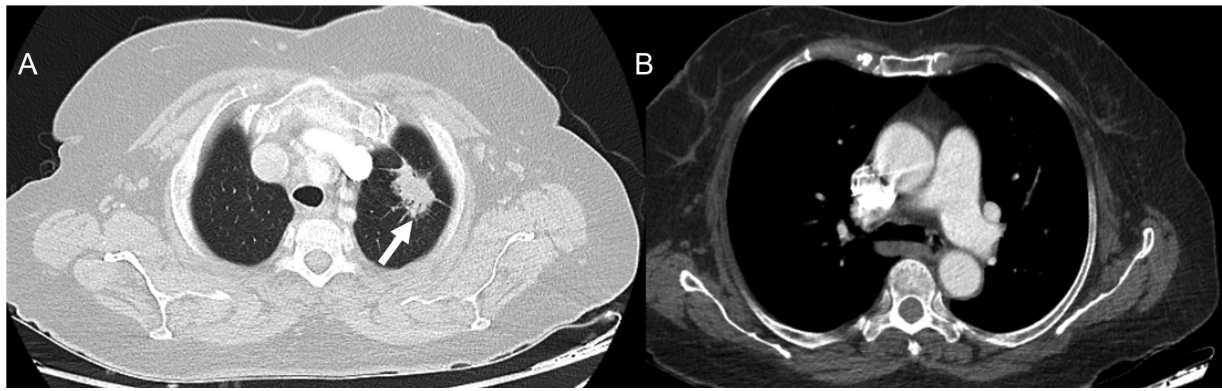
(A) Axial computed tomographic (CT) thorax section in lung window shows a spiculated mass (white arrow) of longest dimension 2.8 cm in the apicoposterior segment of the left upper lobe. (B) Axial CT thorax section in mediastinal window reveals that there are no enlarged mediastinal or hilar nodes. TNM (tumor, nodes, and metastases) stage: T1cN0M0.
